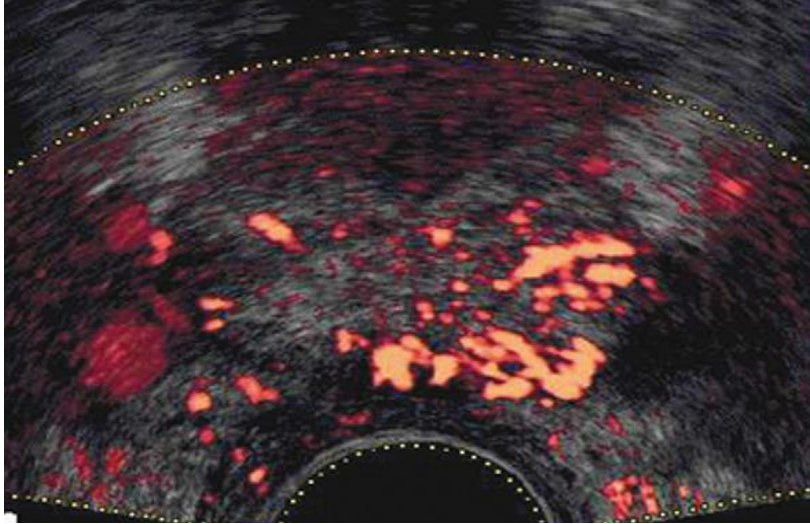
TRUS WITH COLOUR DOPPLER STUDY
